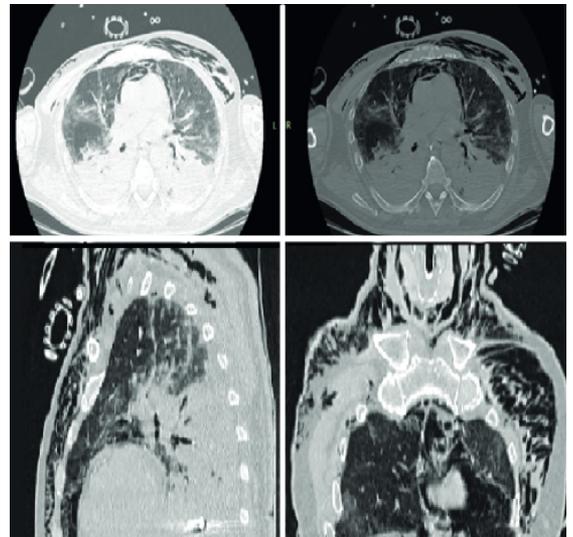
Chest computed tomography (05/04/21 - 4:48 pm). Moderate subcutaneous emphysema, which extends throughout the thoracic and cervical region associated with mild pneumomediastinum. Bilateral diffuse ground-glass pulmonary opacities associated with an extensive area of consolidation in the posterior lung fields, forming an anteroposterior gradient. There are no signs of pneumothorax. Non-selective orotracheal tube.
